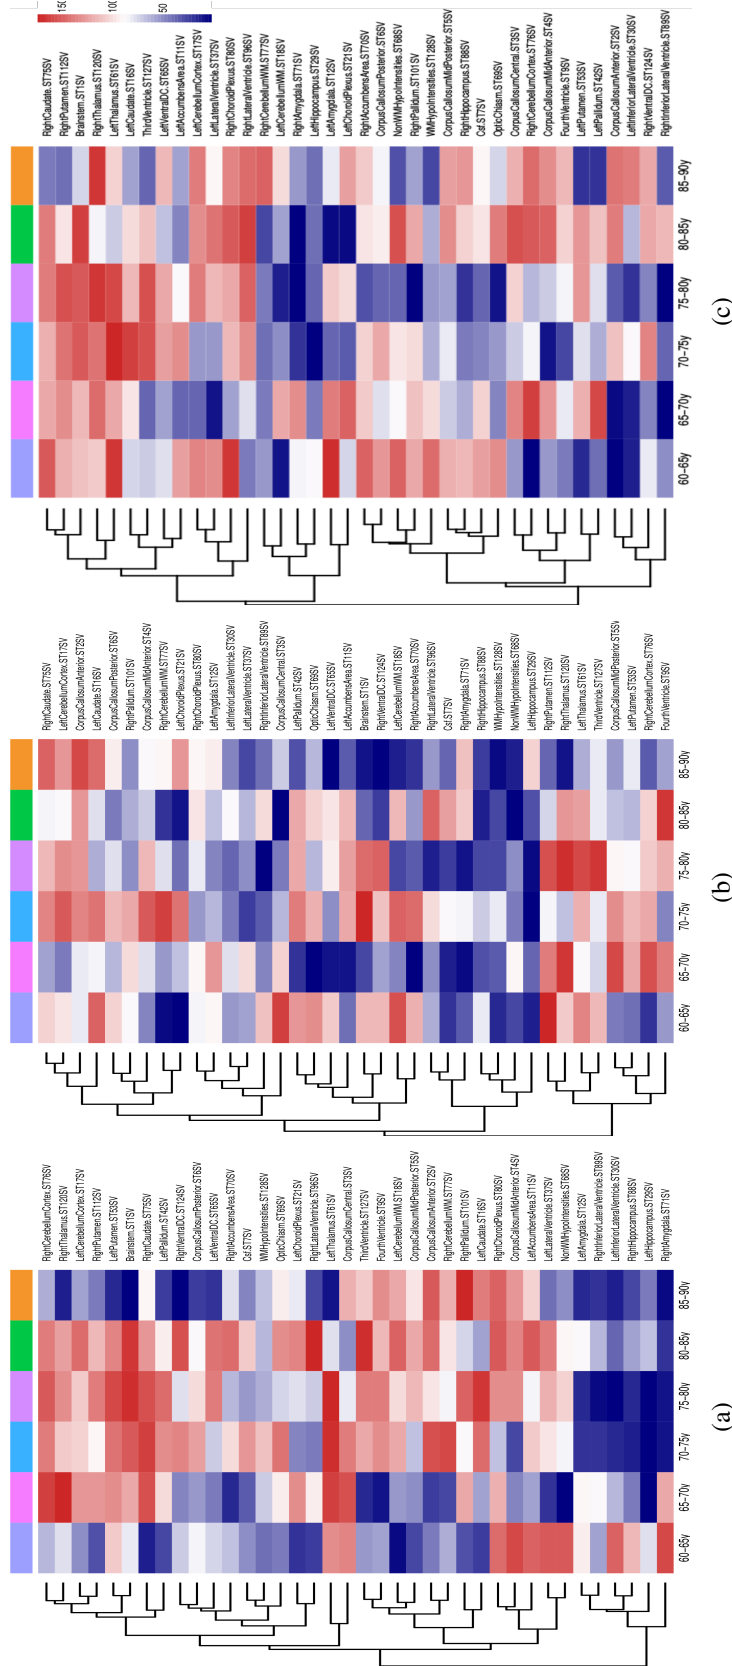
mRMR ranking achieved by the MRI biomarkers of the subcortical region. (a) AD vs HC. (b) MCI vs HC. (c) AD vs MCI. Red colours mean that features were in the lowest ranking positions; blue colours were in the first positions.
